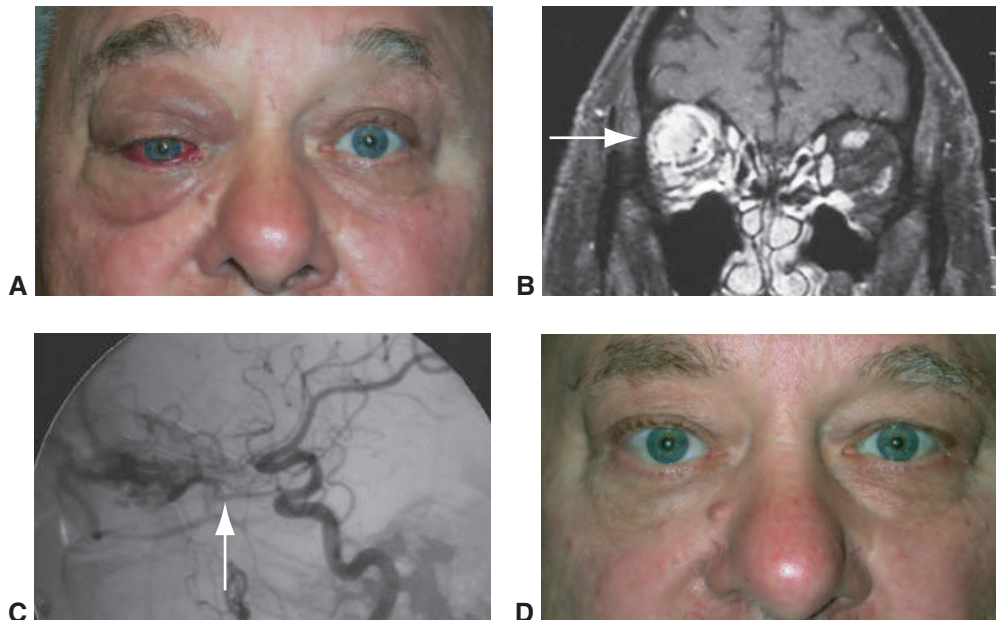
Arteriovenous malformation. A, Arteriovenous malformation in the right eye causing proptosis and arterialization of conjunctival vessels. B, T1-weighted, gadolinium-enhanced MRI shows enhancing superolateral nidus of lesion (*arrow*). C, Angiogram shows enlarged ophthalmic artery (*arrow*). D, Proptosis and arterialized vessels are resolved after embolization and excision of nidus. (Courtesy of Julian D. Perry, MD, and Alexander D. Blandford, MD.)
